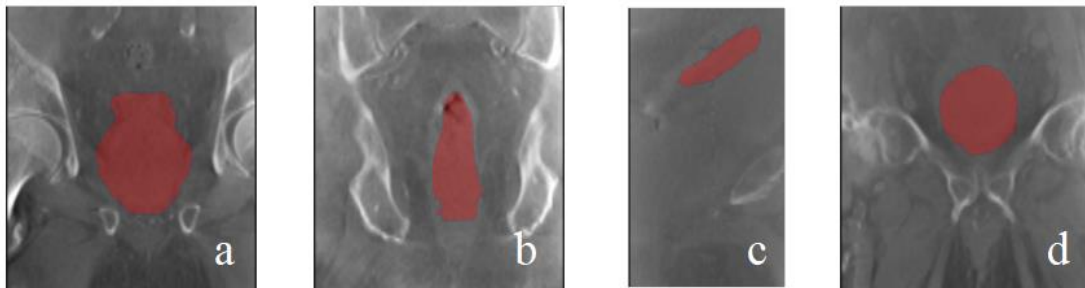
Internal structures of interest. In red it is reported an example of (a) PTV, (b) Rectum, (c) Sigma and (d) Bladder, overlaid on the corresponding CBCT.
